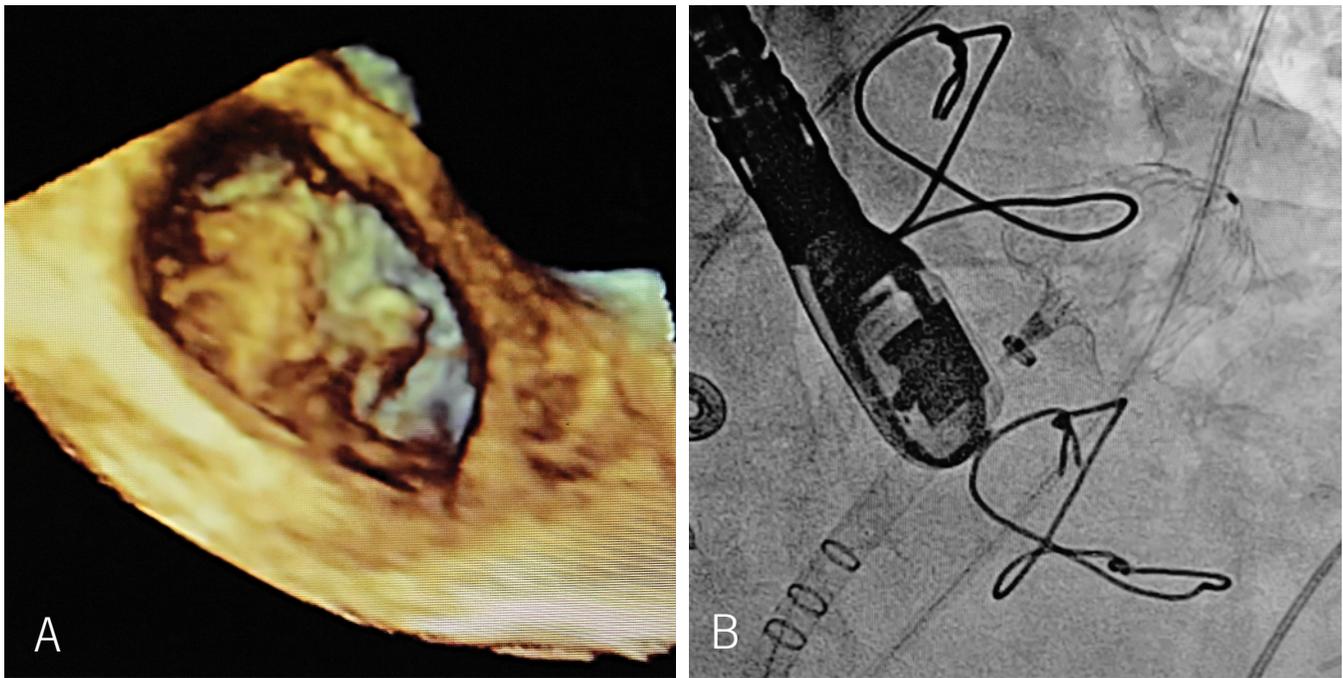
A. Transesophageal echocardiogram in 3D view at a 45-degree angle with a view of an implanted WATCHMAN in the left atrial appendage. B. Fluoroscopic image of a deployed WATCHMAN in an RAO/Caudal view.
